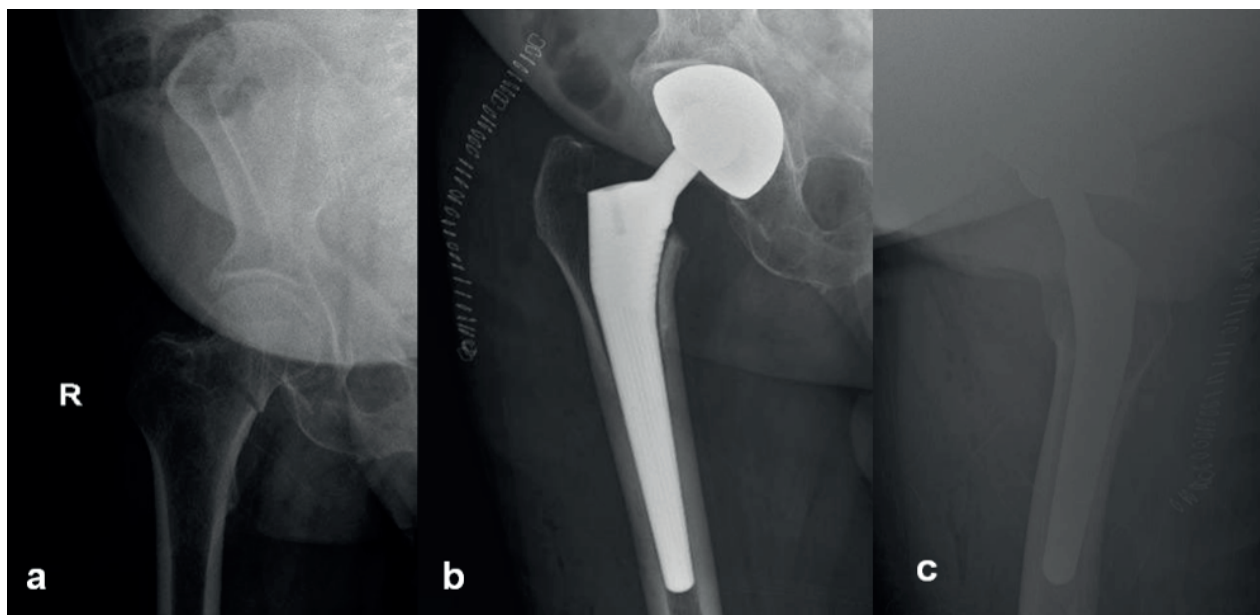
a) Femoral neck fracture in a patient with functional post-traumatic lower limb weakness; b-c) Post-operative x-ray
